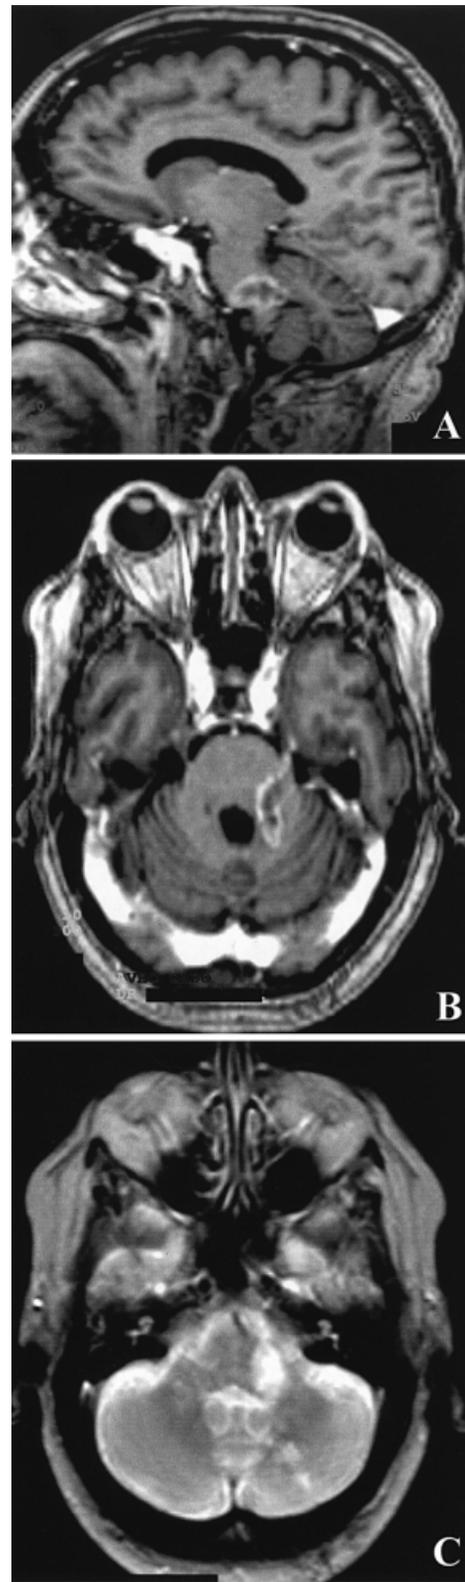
MRI of a patient with a contrast-enhancing localized mass classified as a malignant brainstem glioma. (A) Sagittal T₁-weighted image after gadolinium infusion. (B) Axial T₁-weighted image after gadolinium infusion. (C) Axial T₂-weighted image.
